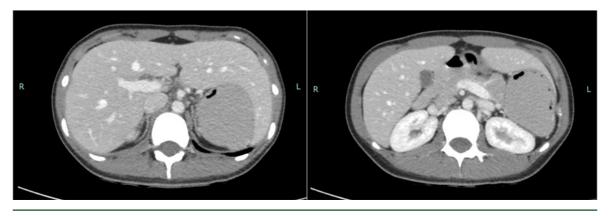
Axial CT abdomen showing absence of spleen in the left upper quadrant.
